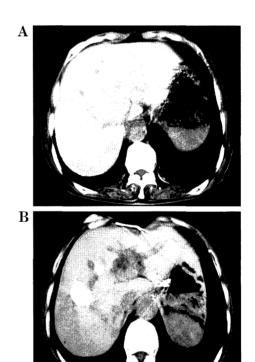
A: Abdominal CT after TAE with OK-432 preoperatively at November 29, 1991. Lipiodol was taken up into the metastatic tumors. B: The tumors decreased remarkably on March 19, 1992.
